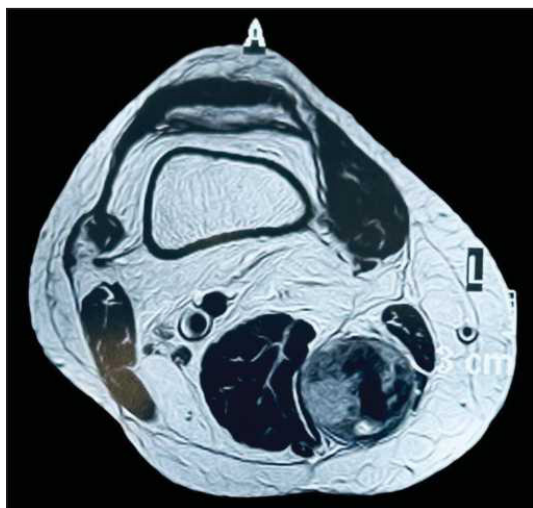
Axial section in CE MRI reveals a heterogeneous mass of size $4 \times 4.2 \times 9.6$ cm in muscle without any continuity to bone.
